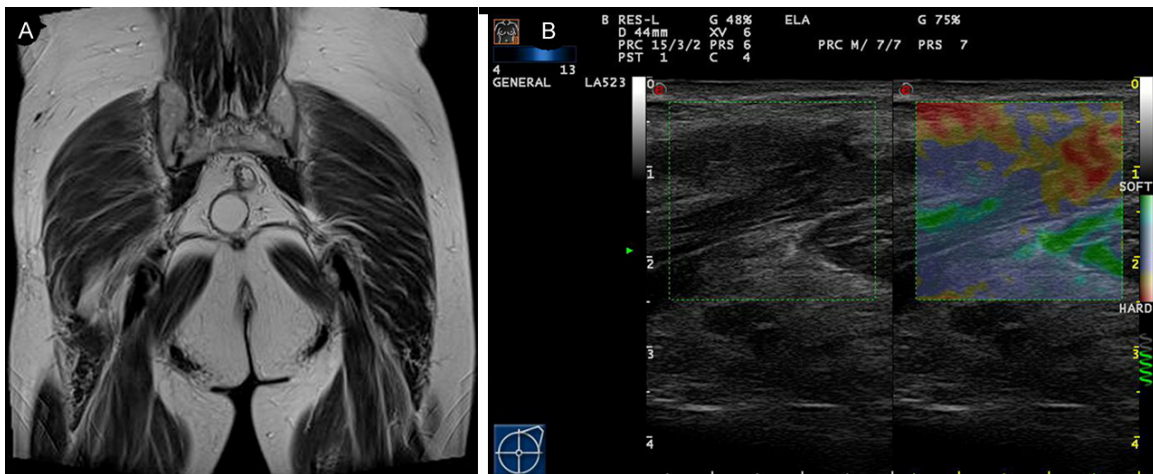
Case 3. A patient of levator ani with no defect detected by MRI (A). ES showed predominantly red and with yellow or green areas comprising between 10% and 50%, scored as ES3 (B).
